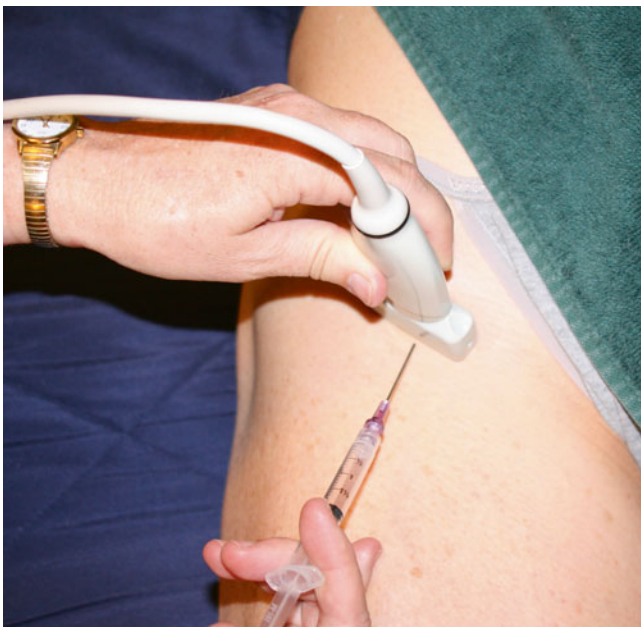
Ultrasound out-of-plane injection of the femoral nerve, showing probe and needle position (Image courtesy of Andrea Trescot, MD)
